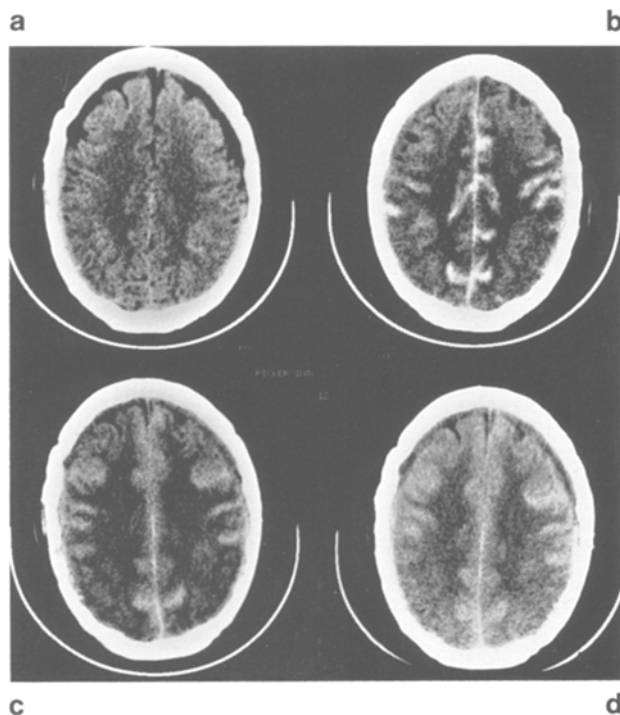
Subdural effusion in a 58-year-old patient (SK). (a) Effusion becomes visible for the first time in the CT scan on day 6 after the trauma. (b–d) CT scans 6, 18, and 24 h after injection of contrast agent; immediate influx of contrast agent into the subdural effusion, free communication between subarachnoid and subdural space
